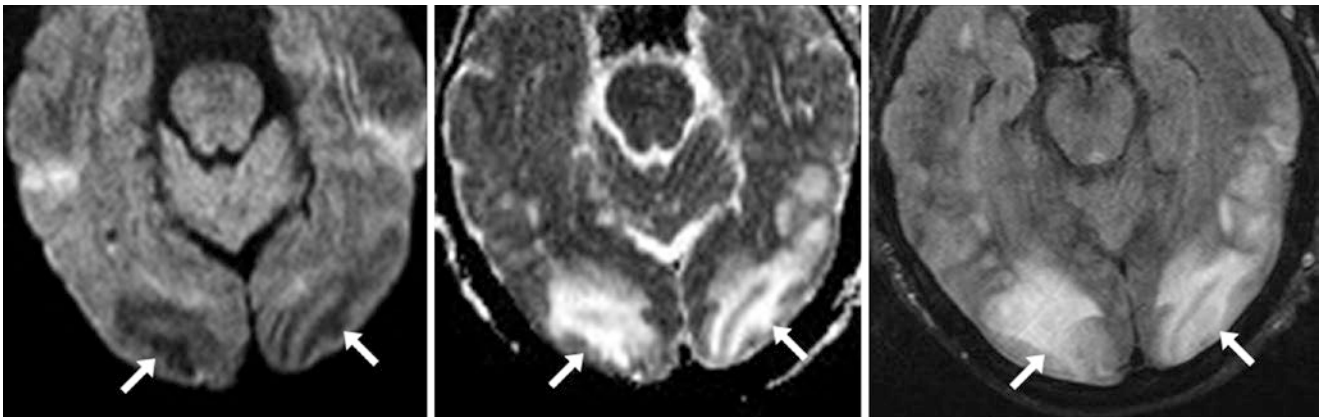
A 1.5 T MRI in a 63-year-old with PRES from cyclosporine. Vasogenic edema (arrows) from PRES causes left parieto-occipital T2-washout on DWI (left), being bright on the ADC map (middle).
